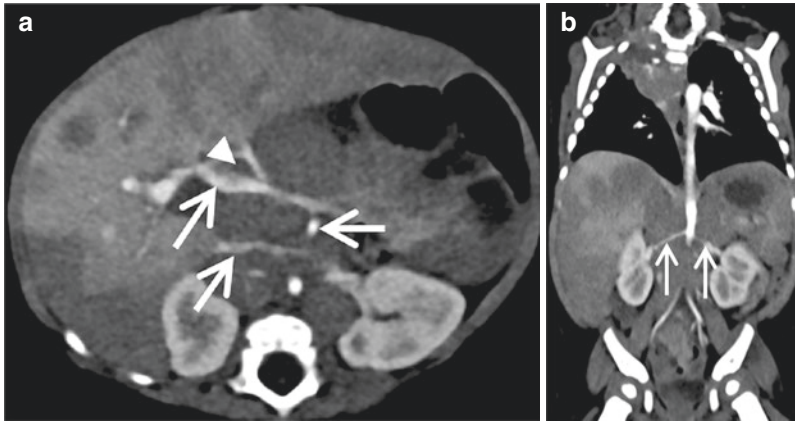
A 3-month-old girl with multifocal neuroblastoma (chest and both adrenal glands) with distant metastases in the liver, pancreas, and bone marrow. Contrast-enhanced CT scan with transverse view (a) and coronal MPR reconstruction (b). IDRFs are present: infiltration of the liver hilum (arrowhead) and encasement of many vessels (arrows): the aorta, the mesenteric artery, both renal arteries, left renal vein, IVC, and portal vein
